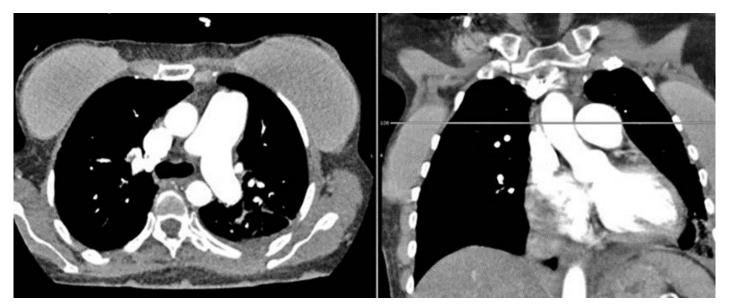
Computed tomography of the thorax of the second patient showing a markedly dilated pulmonary artery in comparison to the aorta.
